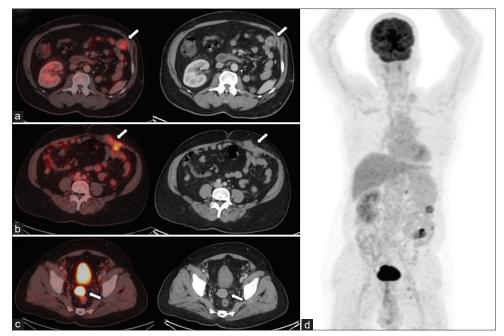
FDG PET-CT study shows hyper-metabolic lesions in the omentum [white arrows in a], at the port site [white arrows in b], and rectovesical pouch [white arrows in c]. (d) represents the MIP image.
